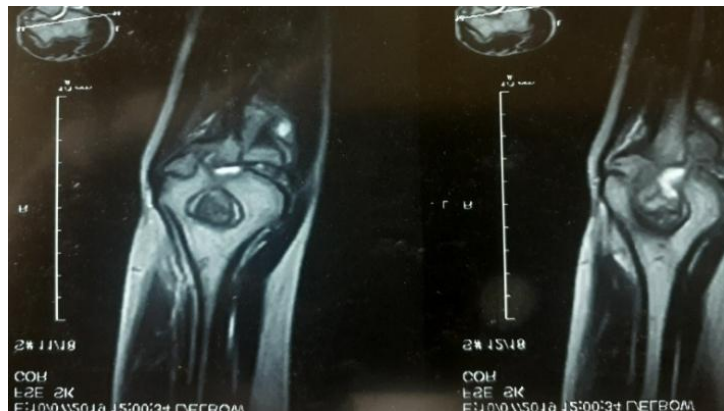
Initial MRI of left elbow showing synovial enhancement, articular erosions, subarticular osteopenia and joint effusion
